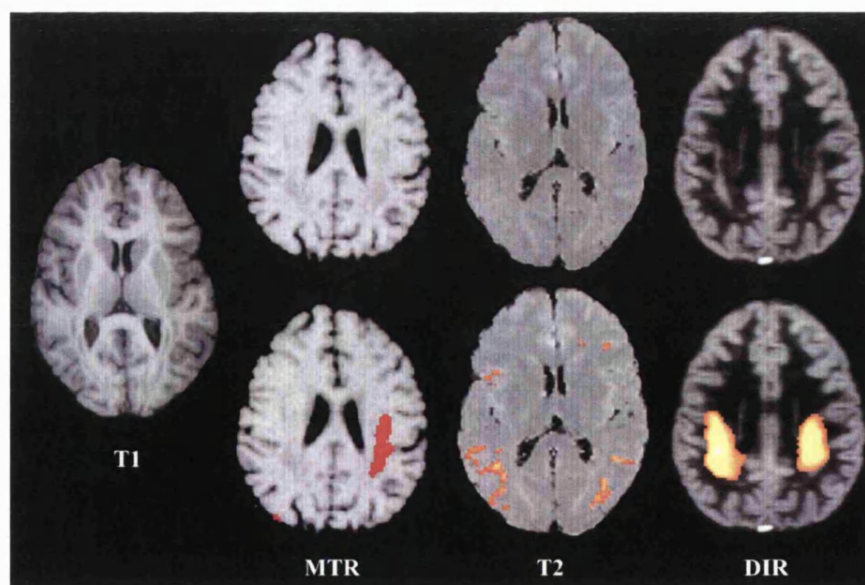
Patient with bilateral, posterior band heterotopia. (Top row, left to right): normalised axial magnetisation transfer ratio (MTR), T2-mapping (T2), and double inversion recovery (DIR) images. (Bottom row): with superimposed regions of significant abnormality identified by SPM. Axial T1-weighted image is also shown.
